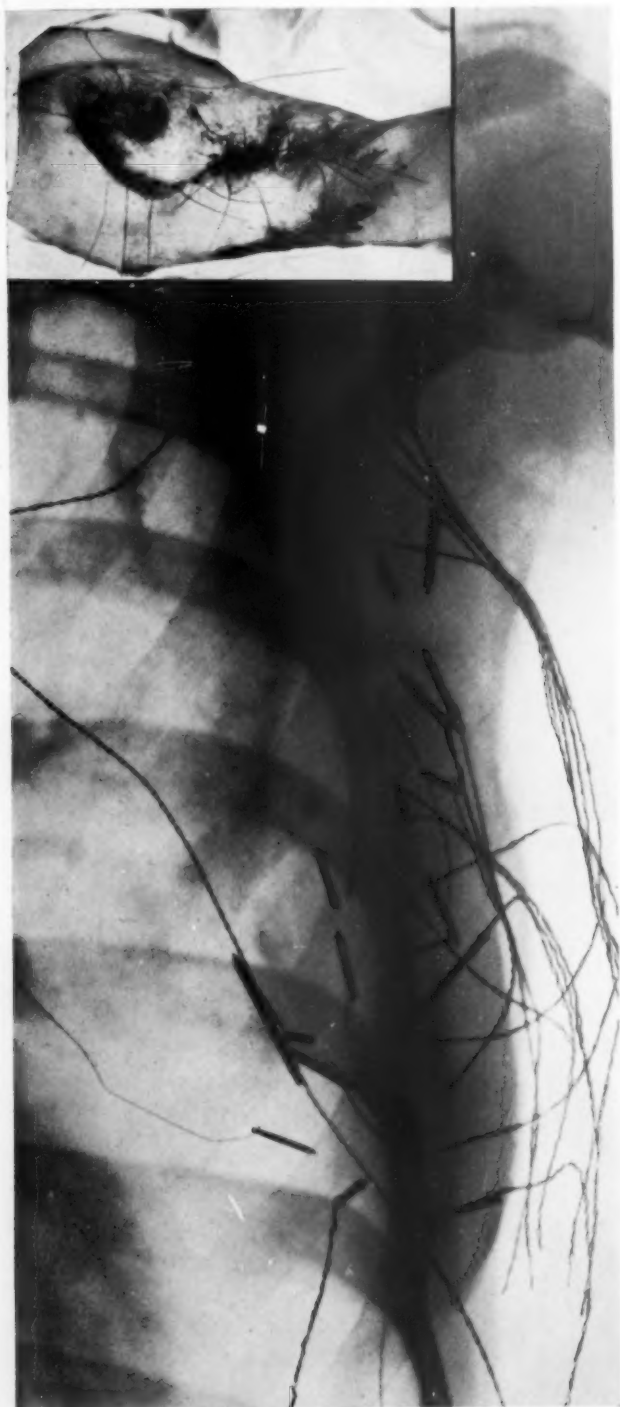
Case No. 1. Radiograph, showing the radium needles inserted about the lesion in the breast and high up in the apex of the axilla in the metastatic glands.
